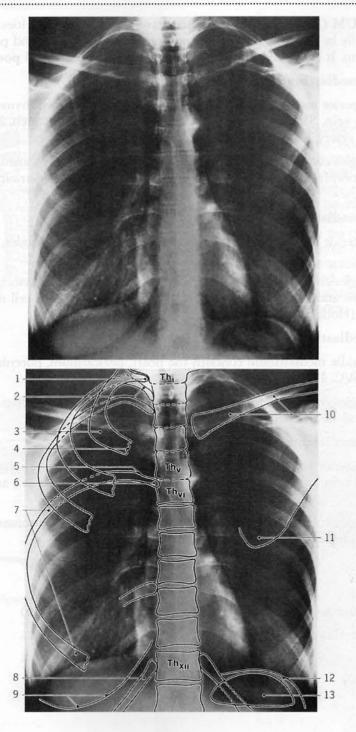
Anteroposterior radiograph of the thoracic cage. 1. Head of first rib. 2. Neck of second rib. 3. Shaft of first rib. 4. Osteochondral junction. 5. Tuberculum of costa 6. 6. Head of sixth rib. 7. Shaft of sixth rib. 8. 12th rib. 9. Breast. 10. Clavicle. 11. Inferior angle of scapula. 12. Diaphragm. 13. Gastric air. (Reprinted with permission from Fleckenstein P, Tranum-Jensen J: *Anatomy in Diagnostic Imaging*. Philadelphia, WB Saunders, 1993, p 200.)
